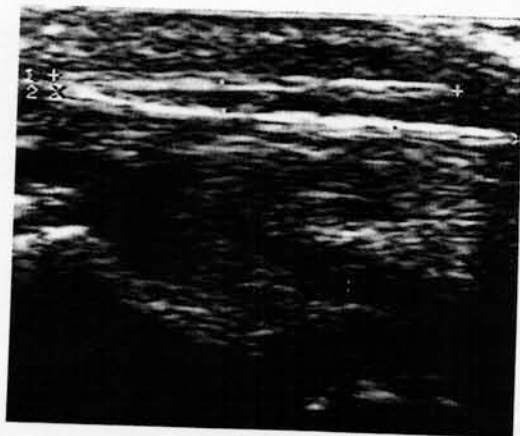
Ultrasonogram demonstrating the retained two pieces of wooden foreign bodies in the soft tissue over the thenar muscles.
